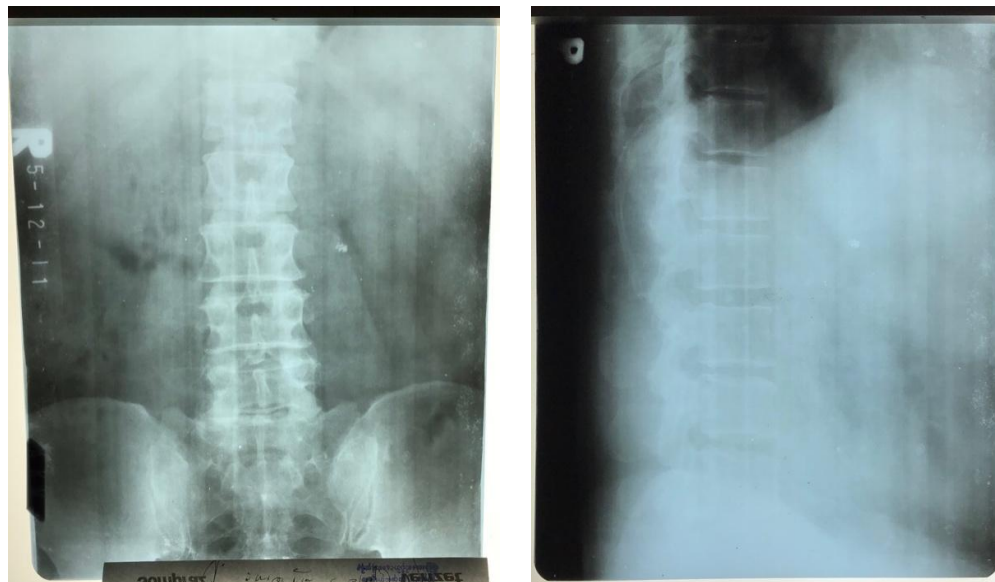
Post-operative 11 years follow-up Lumbar Xray
